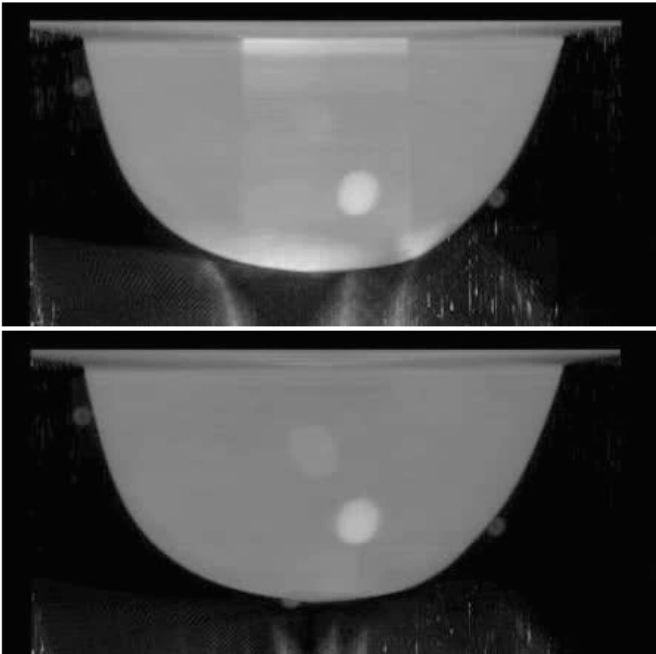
Volume rendering of iteratively reconstructed CT data acquired in an interleaved fashion with a contouring SPECT scan. Images reconstructed using an (TOP) uncropped and (BOTTOM) cropped
